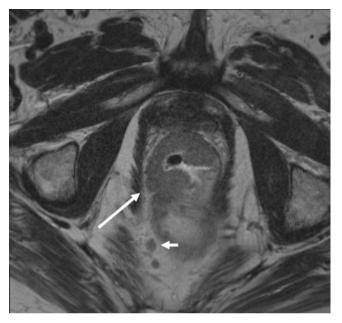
MRI of T3bN1 tumor. Axial T2 image shows a low rectal cancer with focal extension beyond the outer muscular layer (T3b) (long white arrow); positive mesorectal adenopathy (N1: three or fewer nodes) is present posteriorly (short white arrow). (Courtesy of Vincent Pelsser, MD)
